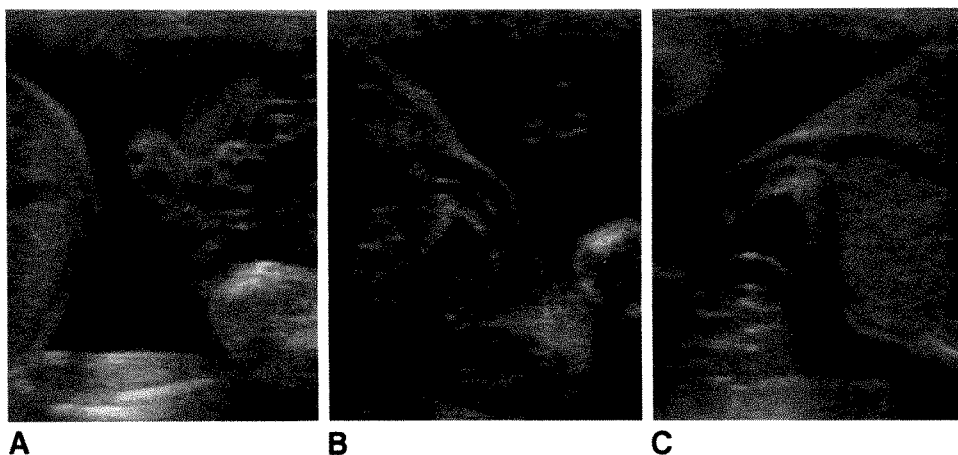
A–C, Monoamniotic twins. During real-time sonography, cord of one twin (B) and that of other twin (C) could be followed to an area where they appear to be entangled (A).
